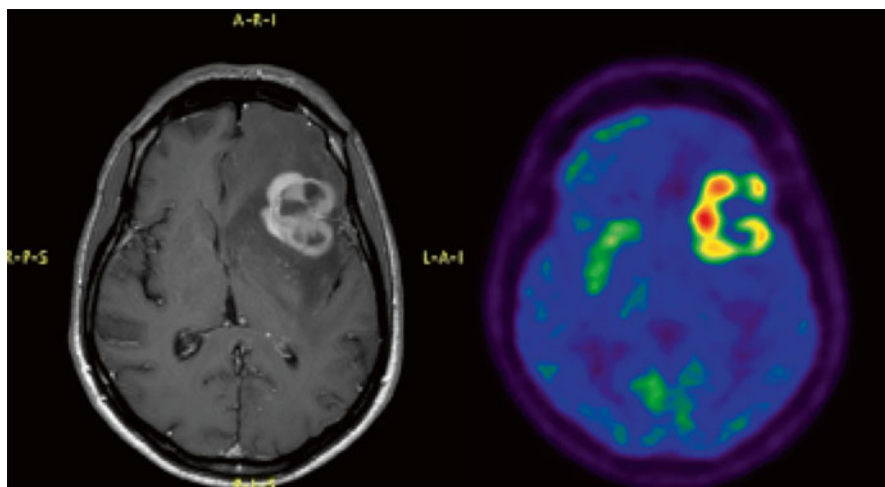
Left:* Gadolinium-enhanced T1 weighted magnetic resonance imaging in a patient with AIDS-related primary central nervous system lymphoma. *Right:* ^{18}F FDG-positron emission tomography in the same patient
